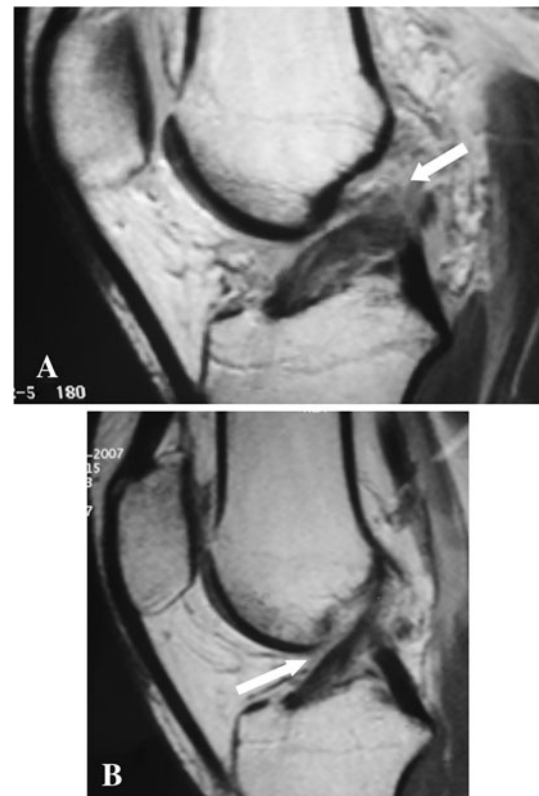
B (A) A MR image sagittal view of the knee shows a complete proximal ACL rupture (arrow). (B) A MR image of the same patient after 2 years shows a continuous ACL (arrow).
